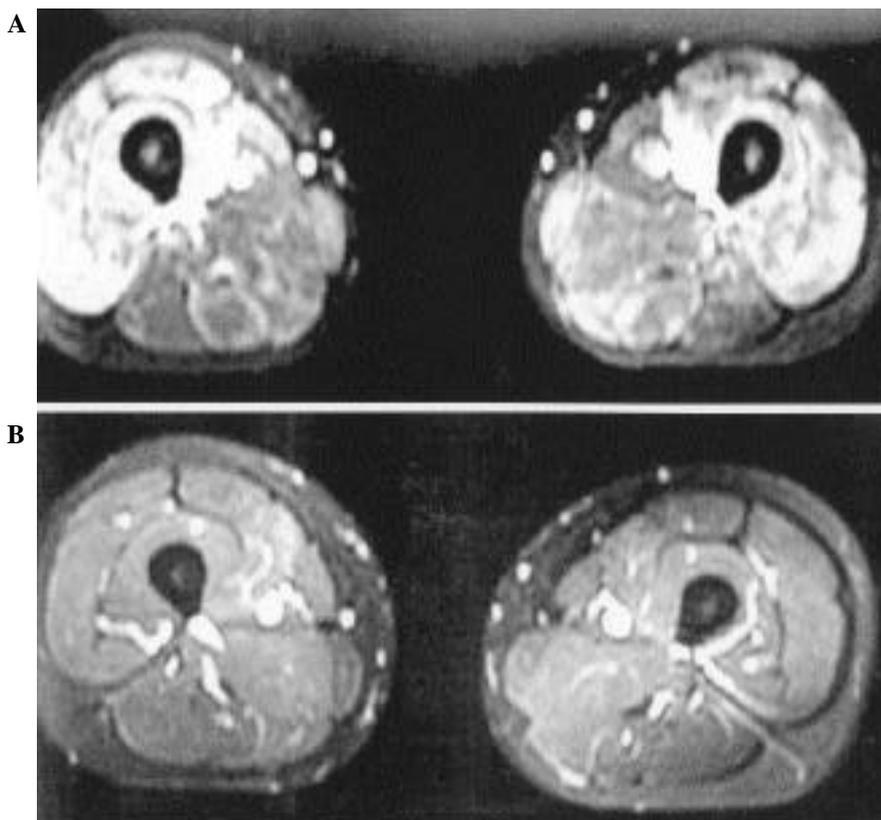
Muscle MRI-STIR of a patient with polymyositis (A) and control scan taken 3 months later (B). Uneven distribution of inflammatory changes in different parts of the thigh. Anterior parts of thigh muscles are severely involved, whereas posterior parts are minimally affected (A).
